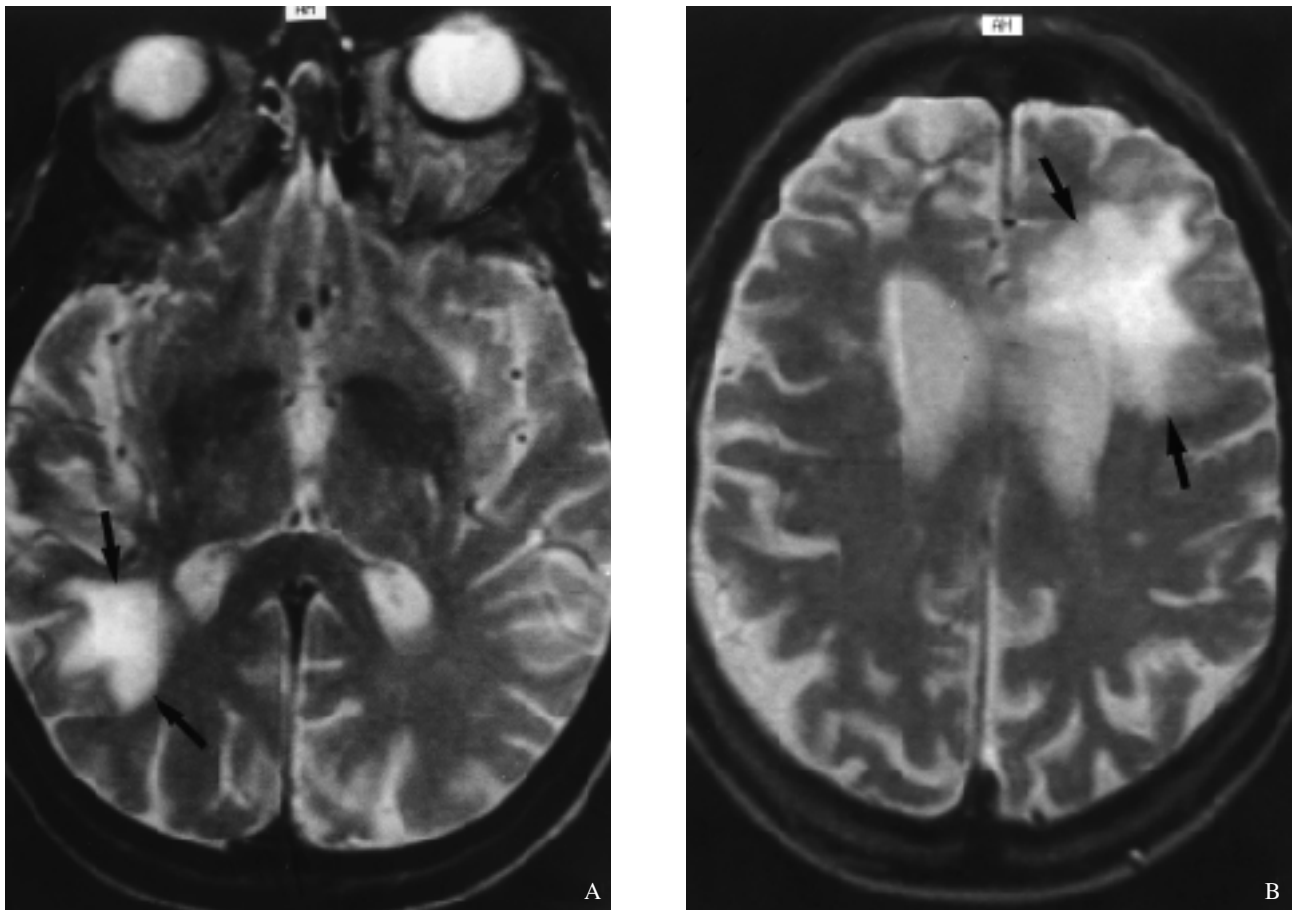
Axial T2-weighted spin-echo MR images (13/05/1997).
